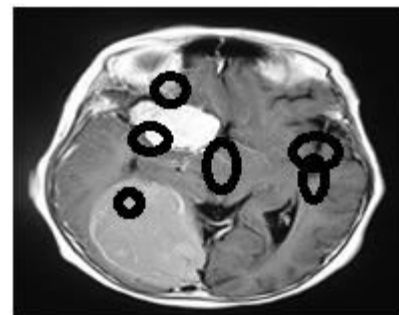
Recovered Medical Images (a) MRI of shoulder (b) CT scan of brain (c) MRI of brain
